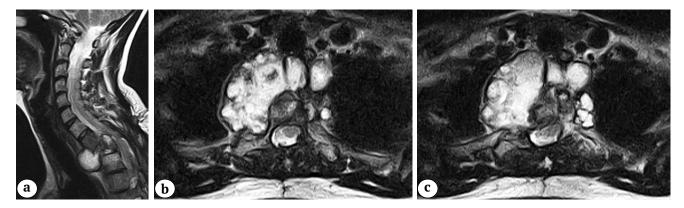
MRI images at the time of hospital admission: a — sagittal view: paravertebral and epidural cystic components, compression myelopathy Th1-3 level; b, c — axial view: polycystic component with heterogeneous structure
